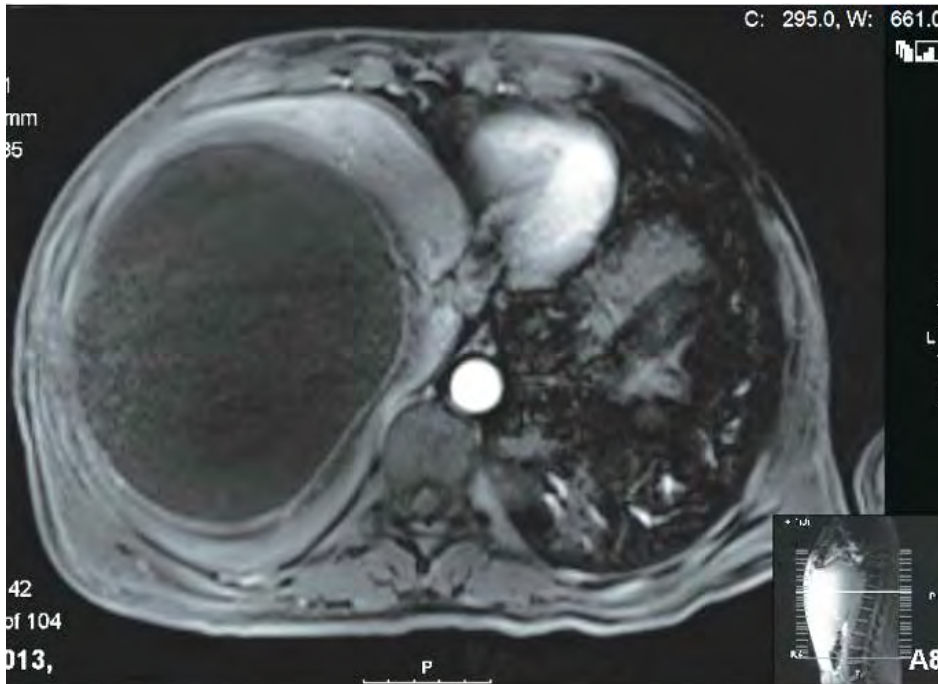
T1 image. MRI showing large hypodense abscess prior to drainage.
